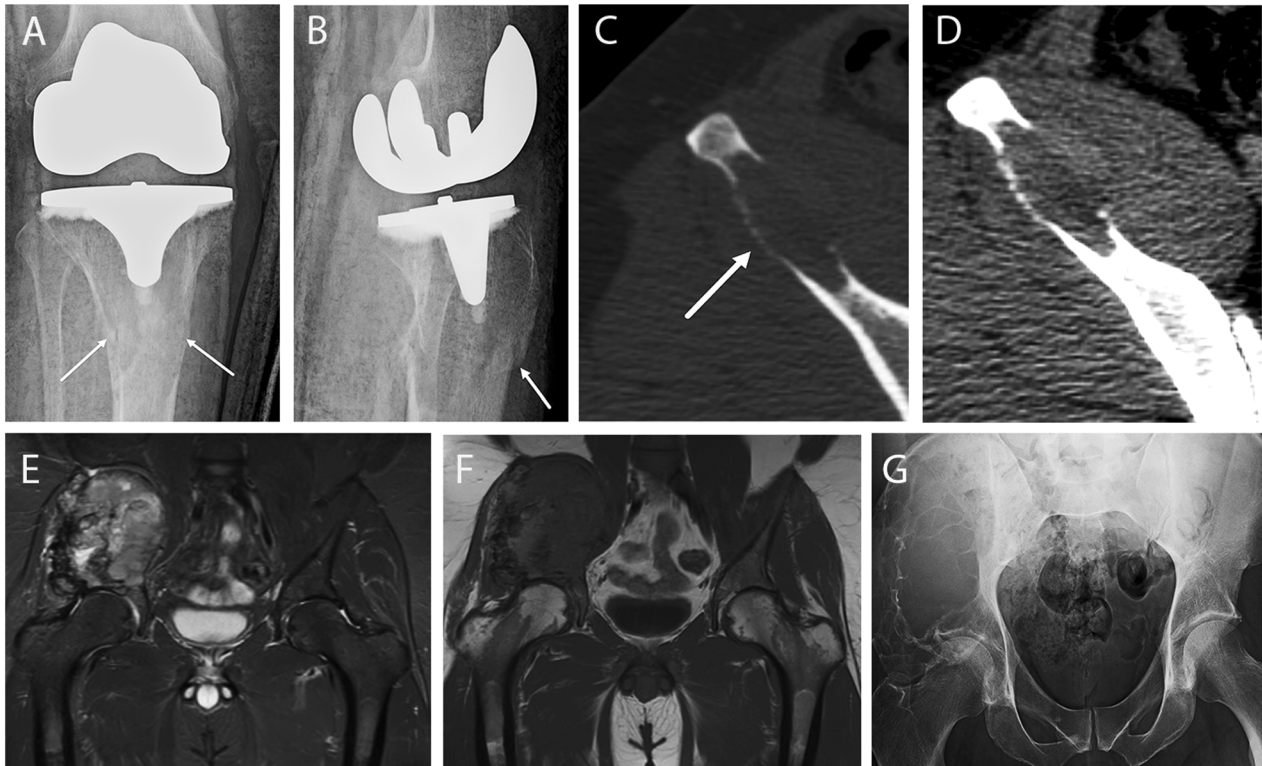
Imaging features of bone tumors. A, B Case 4. A AP and B lateral radiographs of the splinted right knee show an ill-defined lytic lesion (arrows) in the proximal tibia adjacent to the tibial component of a knee arthroplasty. Cortical stepoff (arrow in B) from the fracture is apparent on the lateral view. C–G Case 5. C Axial CT image of the pelvis with bone window obtained at initial presentation shows a lytic lesion in the right iliac wing with permeation of the outer table (arrow) and complete cortical destruction of the inner table. D Axial CT image with soft tissue window depicts heterogeneous attenuation within the lesion. E Coronal short tau inversion recovery (STIR) and (F) coronal T1-weighted MR images obtained following denosumab therapy. These show extensive interval expansion of the bone lesion, which now occupies the majority of the iliac bone and gives rise to a large soft tissue mass both medial and lateral to the bone. G AP pelvic radiograph obtained simultaneous to the MRI demonstrates near-complete erosion of the right iliac wing by a lytic, expansile bone lesion that thins the cortex and contains no discernible matrix.
